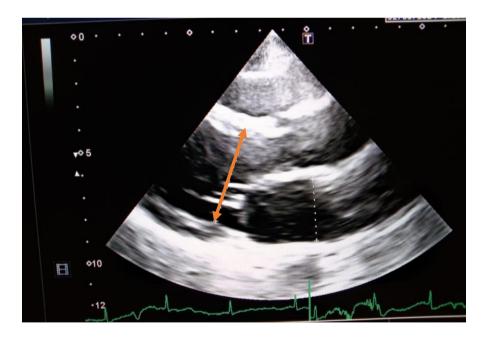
Echocardiographic image measuring systolic dimension of the left ventricle in parasternal long-axis view from the current study conducted at NICVD, Karachi.
